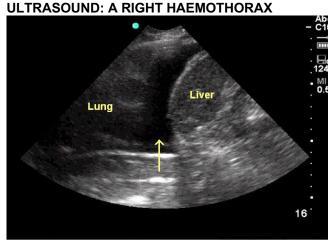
ULTRASOUND IMAGE OF A RIGHT HAEMOTHORAX. Blood shows as a dark homogenous zone between the diaphragm and the lung.
